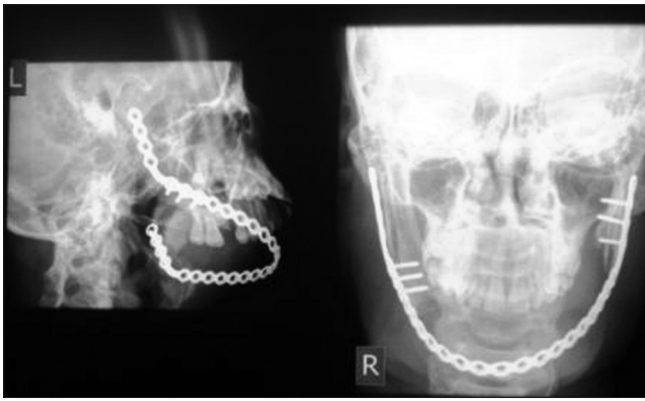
Plain radiographs showing the alloplast *in situ*
